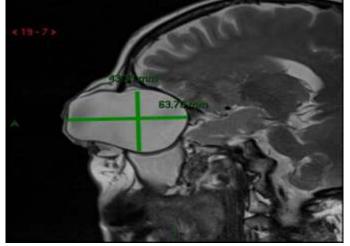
C: Sagittal T2W MRI orbit, $6.3 \times 4.3 \text{ cm}$ (AP x TR) mass noted in eye.
